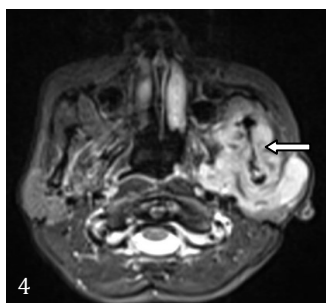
MRI T2 Fat suppressed axial section: Homogenous hyperintense lesion.
